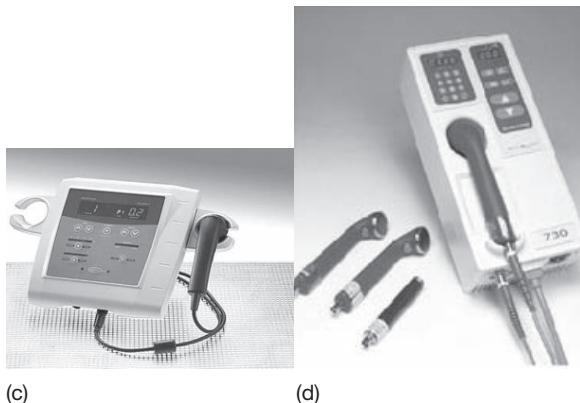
Ultrasound Units (a) Intellect Transport (b) Intellect Legend (c) Accusonic Plus (d) Sonicator
